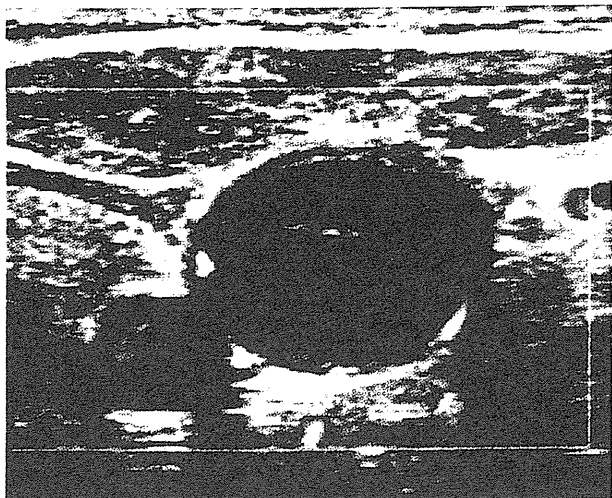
Color doppler ultrasound revealed a left internal jugular vein thrombus.
